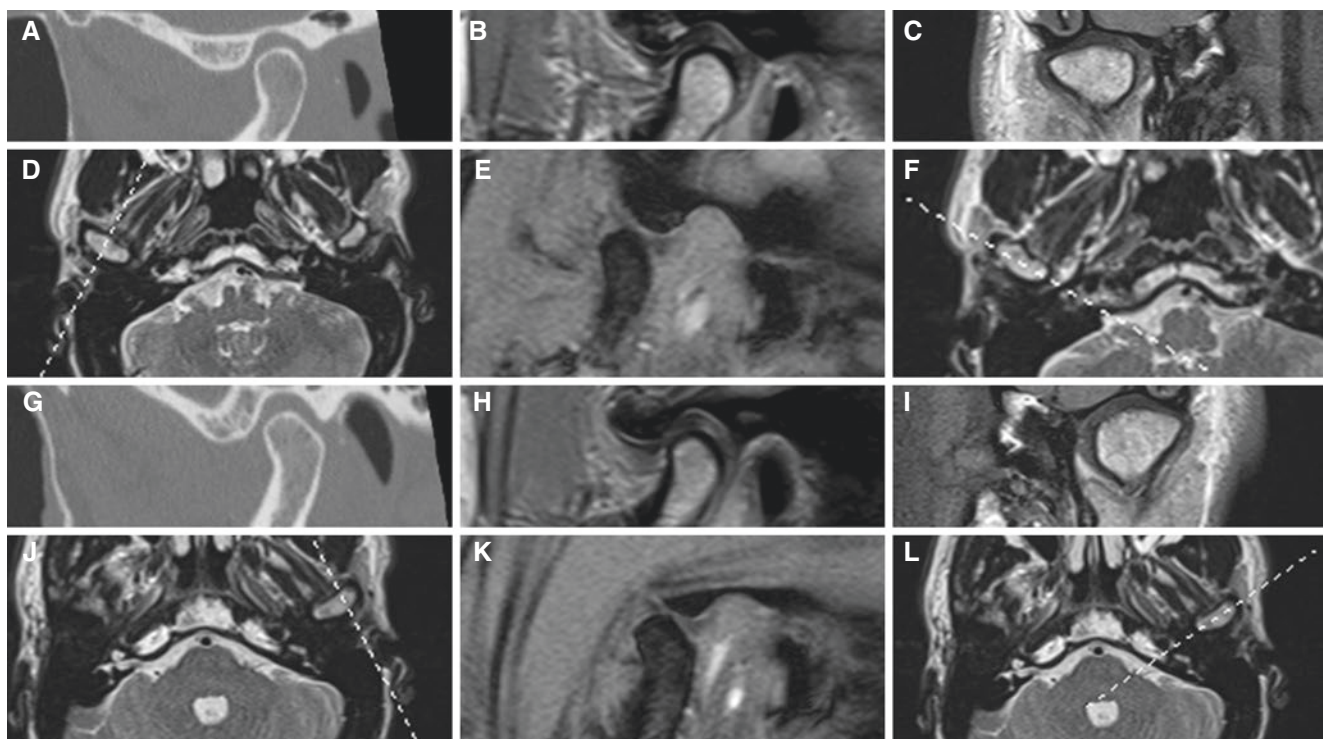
Normal temporomandibular joint bone, disc, and function; 47-year-old male with myalgia. (A–F) Right joint. (G–L) Left joint. (A, G) Oblique sagittal CT at closed mouth. (B, H) Oblique sagittal MRI at closed mouth. (C, I) Oblique coronal MRI at closed mouth. (D, J) Axial
